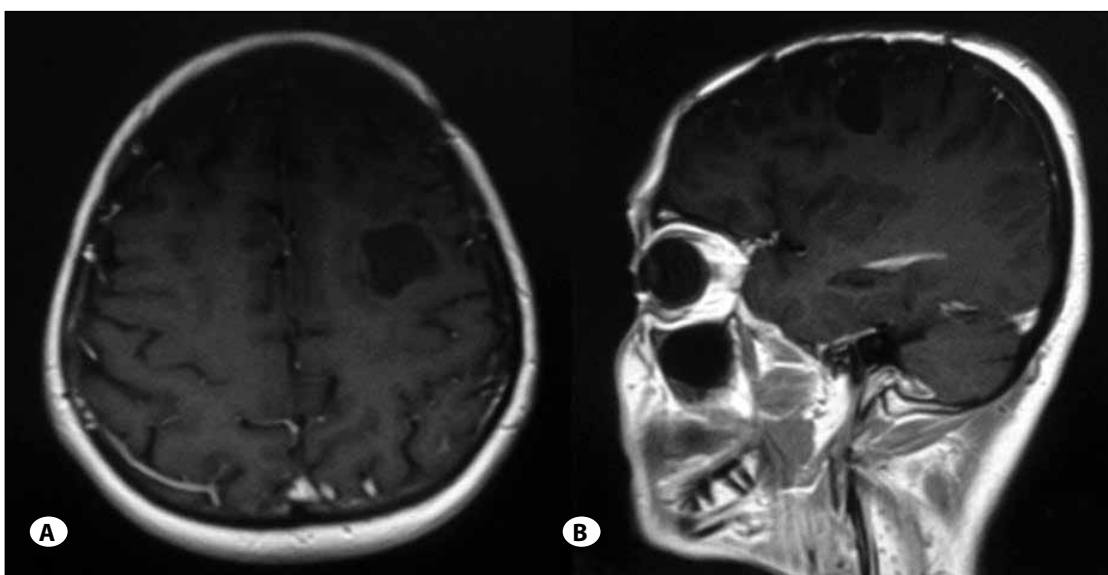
Postoperative T1-weighted contrast enhanced magnetic resonance images confirm porencephalic cyst in A) axial, B) sagittal planes.
